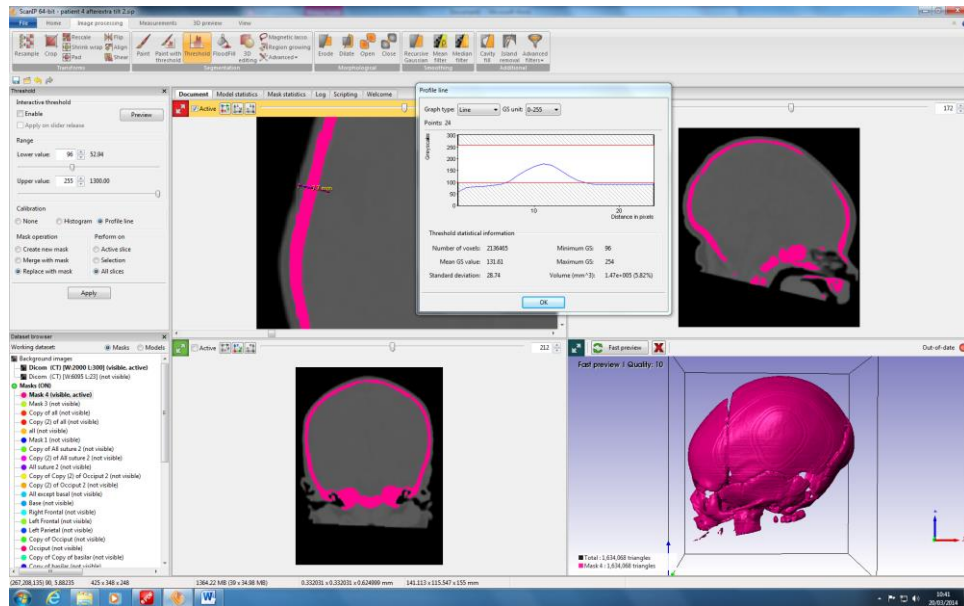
Threshold filter applied to the CT dataset and image then aligned with Frankfort plane.
